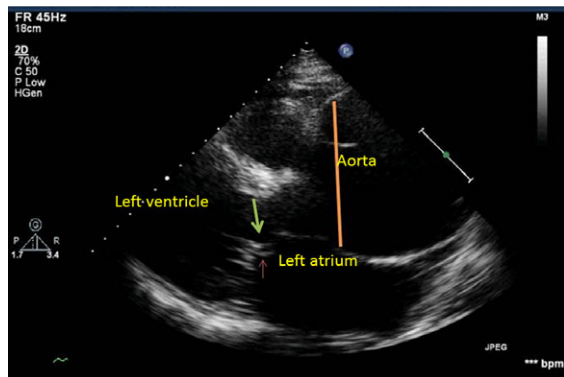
Parasternal long-axis view showing dilated aortic root (line). Notice also the reversed doming of the anterior mitral valve secondary to severe aortic regurgite (arrow).
